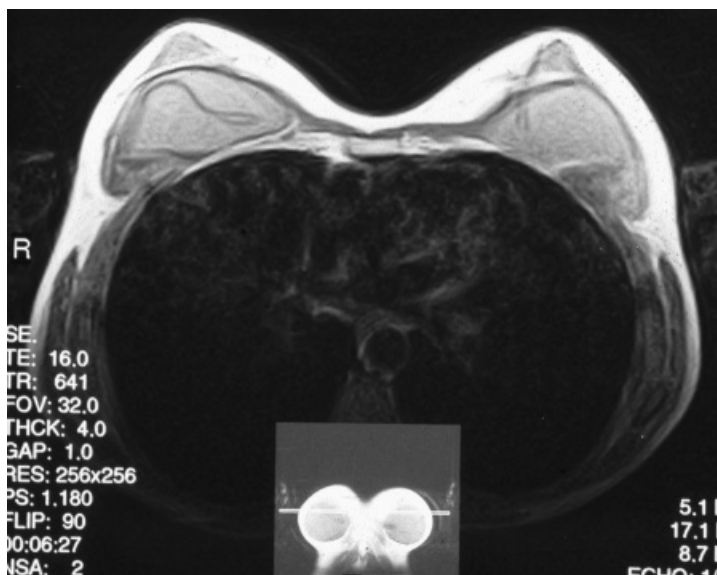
Ruptured right breast implant on magnetic resonance imaging
